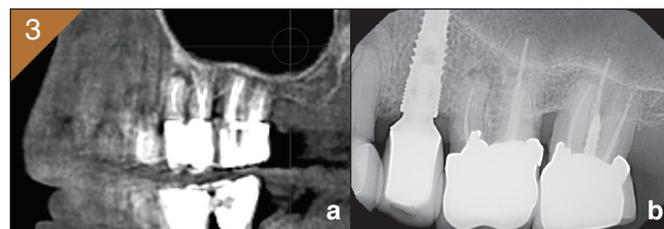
a) CBCT of the failing maxillary left molars, b) Pre-op periapical.
